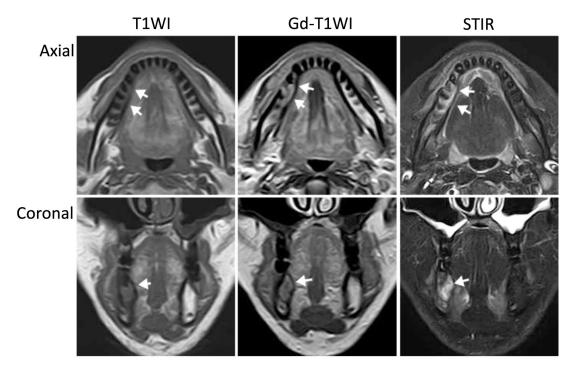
Enhanced T1-weighted MRI showing the mass with low intensity (*arrow*). Short inversion time inversion recovery (STIR) image showing high signal intensity. A solid and ununiformity lesion was seen at this site (*arrow*).
